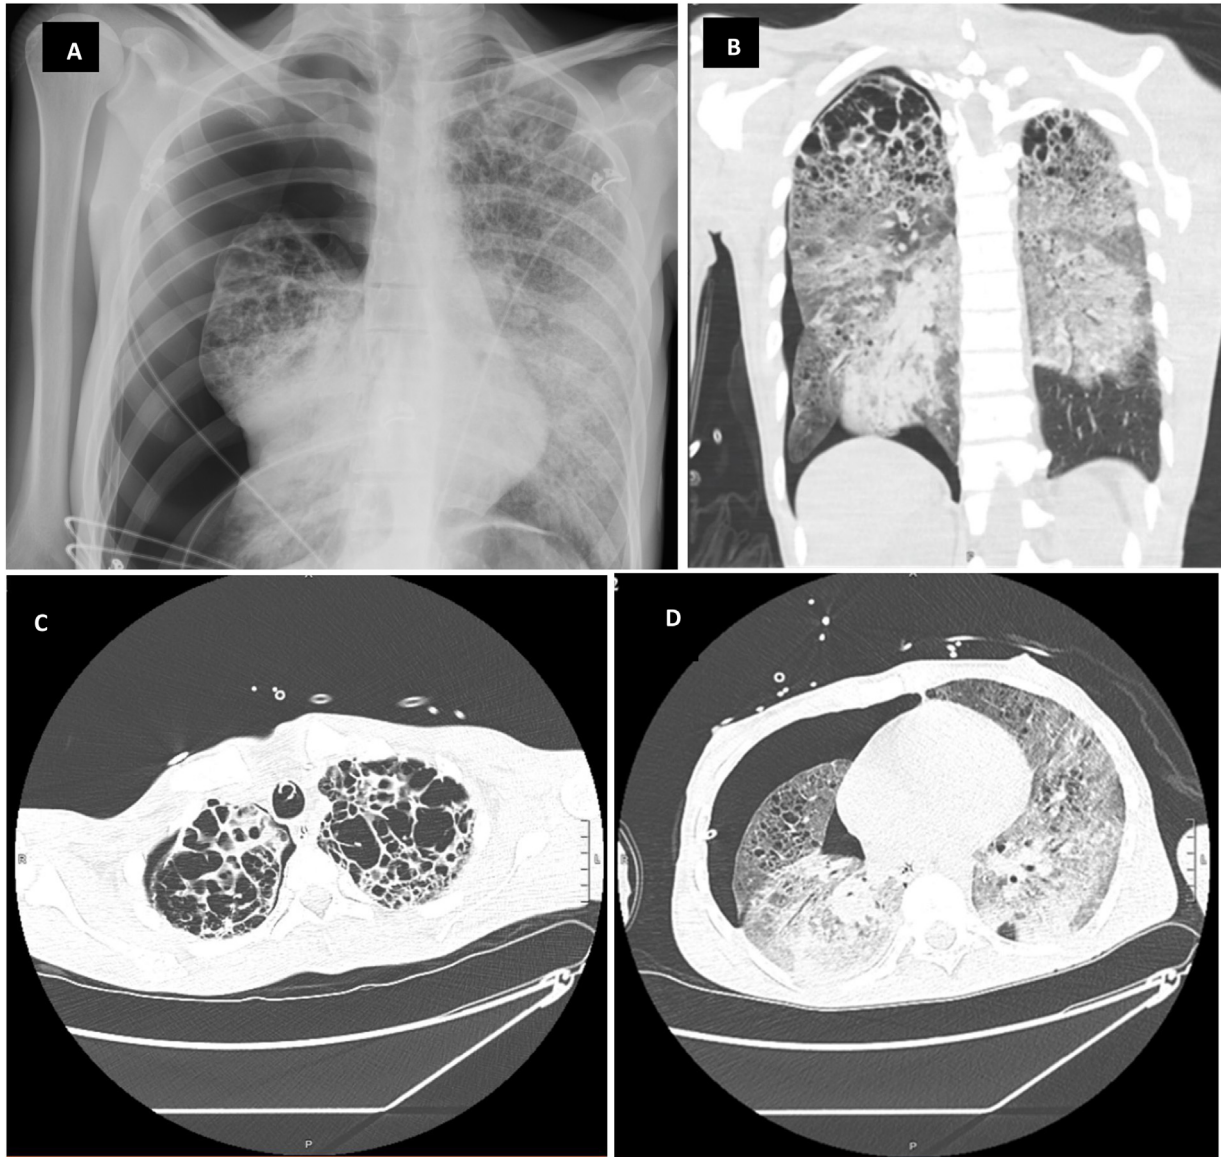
Chest X-ray and CT of the chest on presentation. (A) Chest X-ray showing a large right pneumothorax and extensive interstitial disease. (B) CT chest coronal view showing apical cystic changes, diffuse ground-glass opacities, dense consolidation, and pneumothorax. (C) Axial view of predominant apical cystic changes. (D) Axial view showing diffuse ground-glass opacities and right pneumothorax with the chest tube present.
